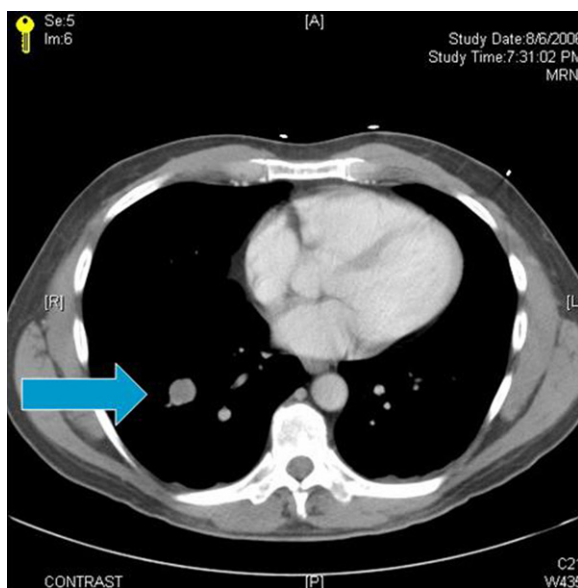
CT scan of chest with arrow indicating a well-circumscribed, solitary mass.
